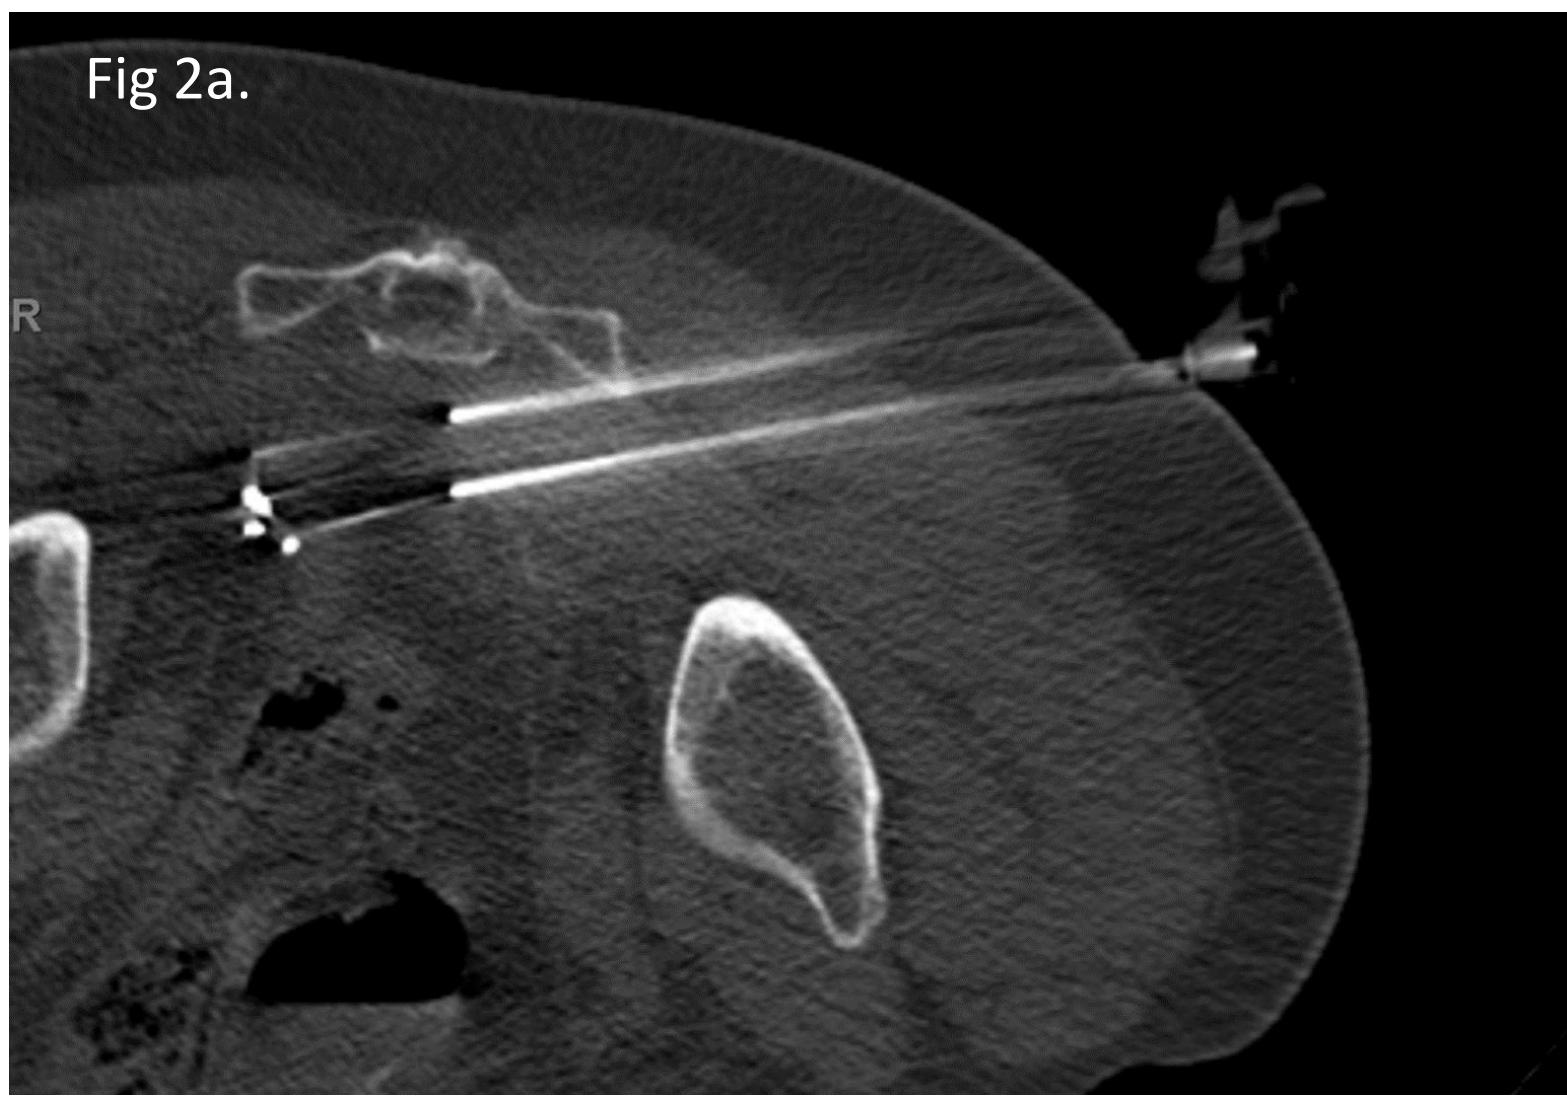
Patient 1 Intraprocedural CT. 2a. Axial view, 2 IRE probes. Streak artifact from a fiducial marker and endovascular coil between probe tips.
